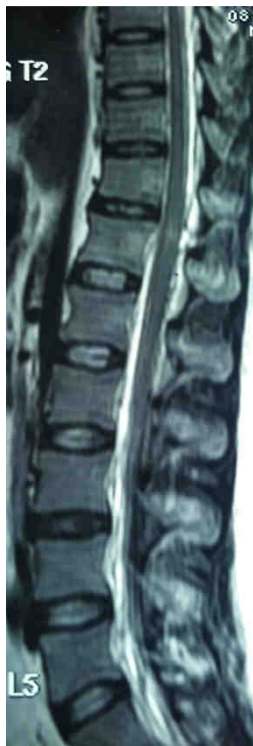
MRI dorsolumbar spine showing hyper intense signal in spinal cord at upper border of D12 level without cord compression
